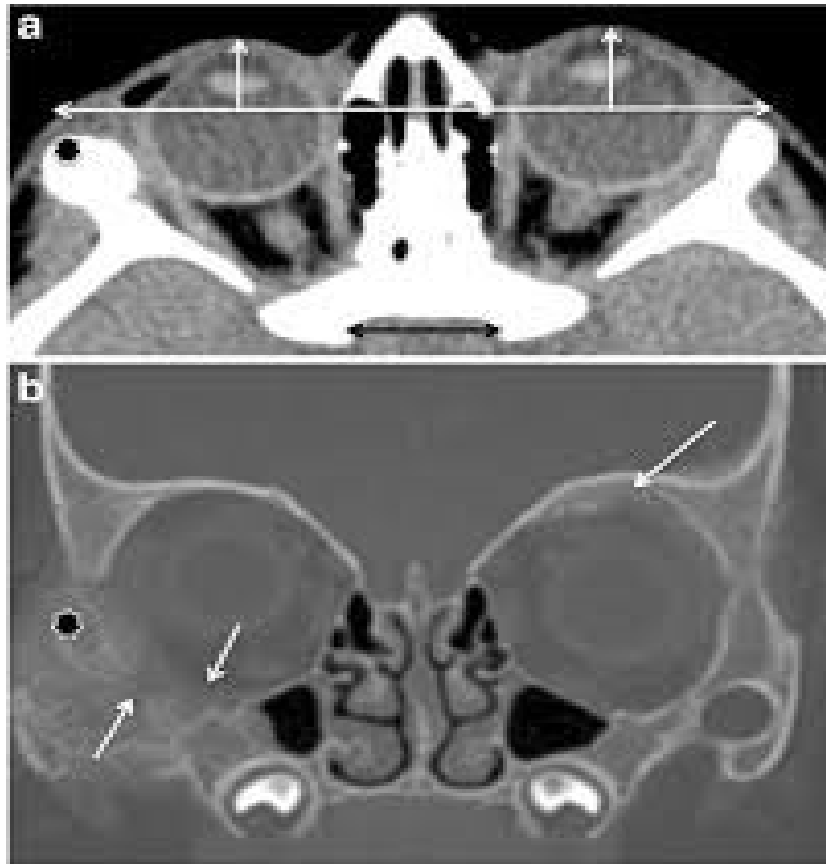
Orbit CT scan for eye tumour [27].
